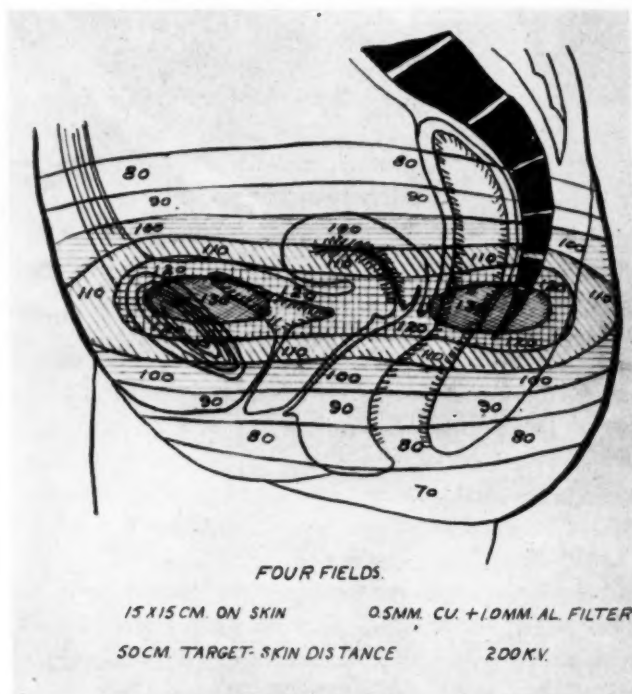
Sagittal section of average female pelvis. Showing distribution of radiation from X-ray pelvic cycle—four fields—15 by 15 centimetres on skin, 200 kilovolts, 0.5 millimetres copper and 1 millimetre aluminum filter, 50 centimetres target-skin distance. One erythema dose to each area.
